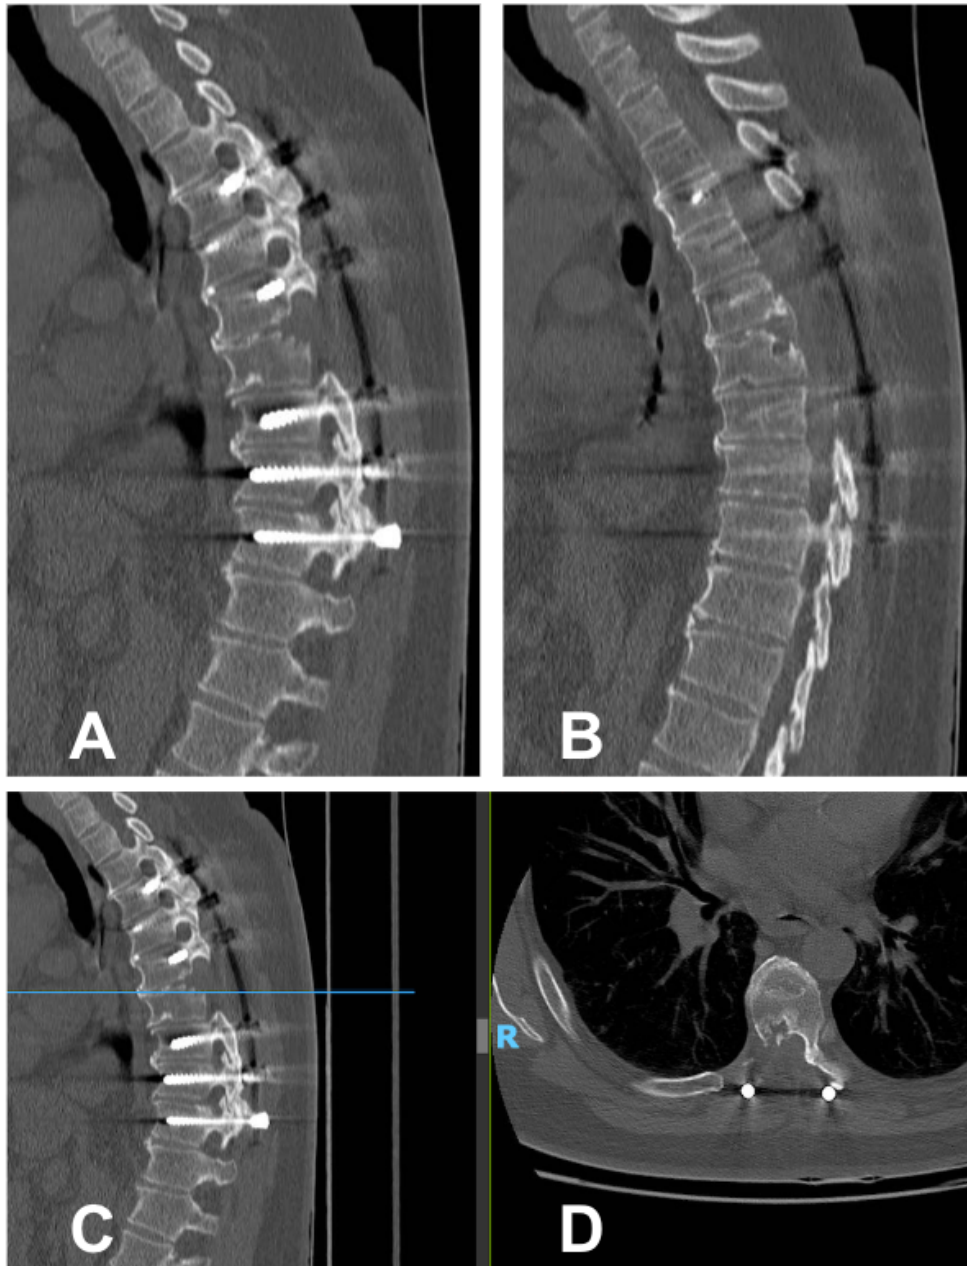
CT of the dorsal spine, sagittal (A, B, and C), and axial (D) section. Two years follow-up shows postoperative changes without evidence of local recurrence, satisfactory spinal cord decompression, and a solid fusion mass from T4 to T10.
